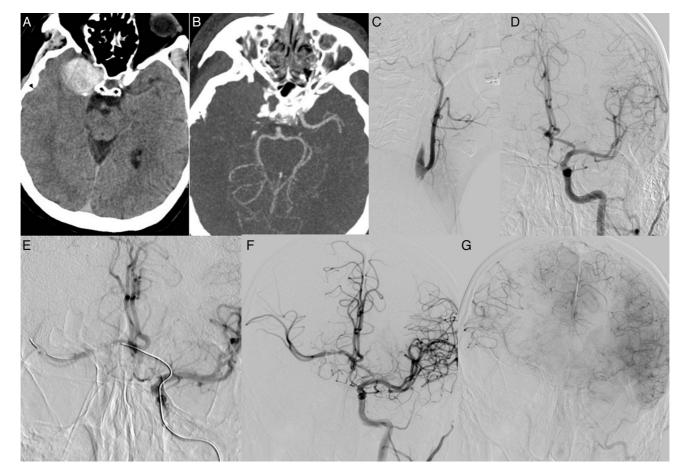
(A) Hyperdense lesion in the region of the cavernous segment of the right ICA corresponding to a thrombosed giant aneurysm. (B) CT-angiography of the circle of Willis revealing no blood flow in the right MCA territory. (C) Digital subtraction angiography with contrast injection into the right CCA revealed no blood flow in the right ICA. (D) Angiography of the left CCA (intracranial projection) showing no abnormalities in the ACoA, adequate filling of the distal portion of right A1, right ACA elevation, and T occlusion in the terminal segment of the right ICA. (E) Selective catheterisation of the right ACA and MCA via the ACoA. (F) Use of Enterprise stents between the right MCA and the right carotid artery. (G) Angiography (parenchymal phase) showing recanalisation type 2b according to the mTICI scale, associated with delayed venous drainage compared to the left hemisphere.
